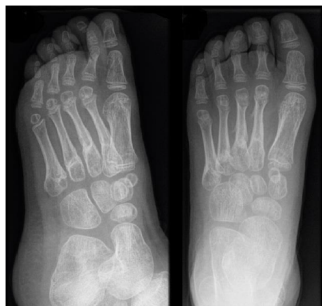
Final X-ray after 4 weeks.
